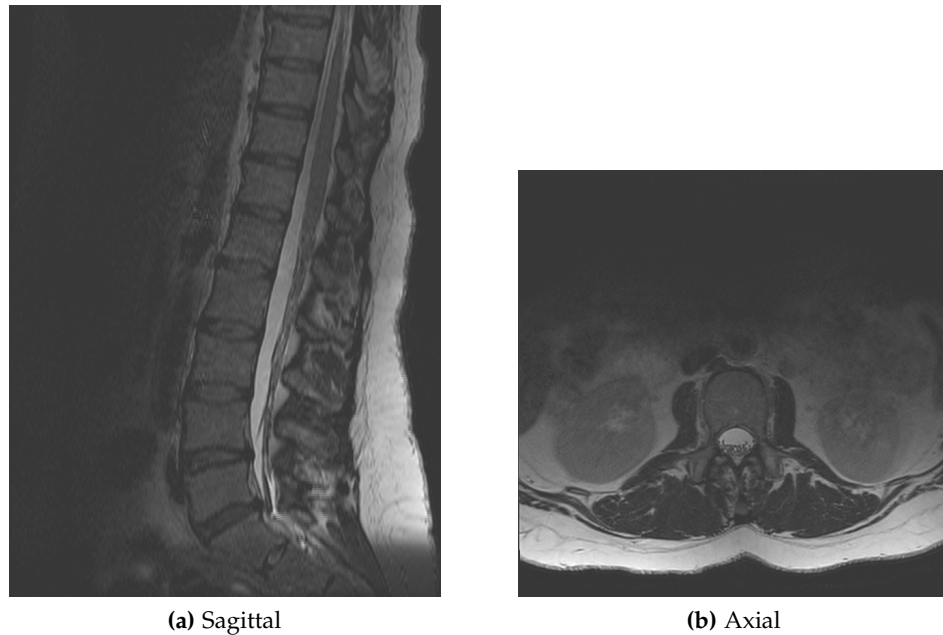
Cross-sections of an MR image with pronounced intensity inhomogeneity. The effect can be most easily noticed on the subcutaneous fat (bright white) in both cross-sections.
